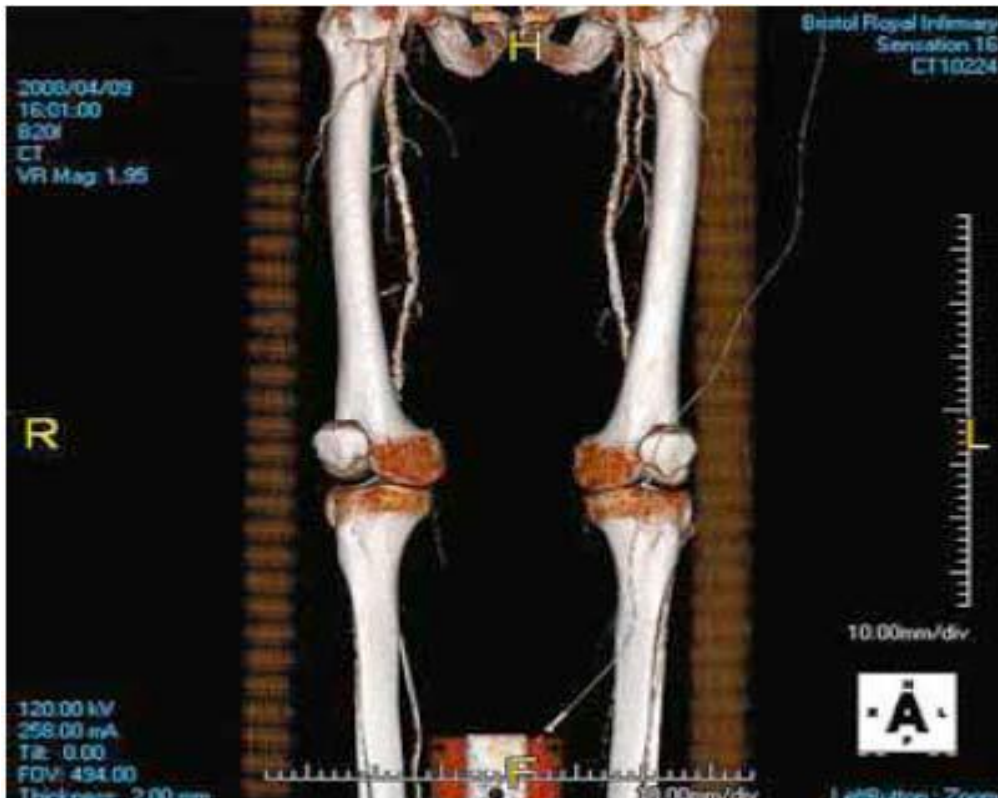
Contrast computed tomography angiography demonstrating diffuse, nonocclusive, stenotic right superficial femoral artery disease. (Quoted from Hamik and Creager , 2008)
